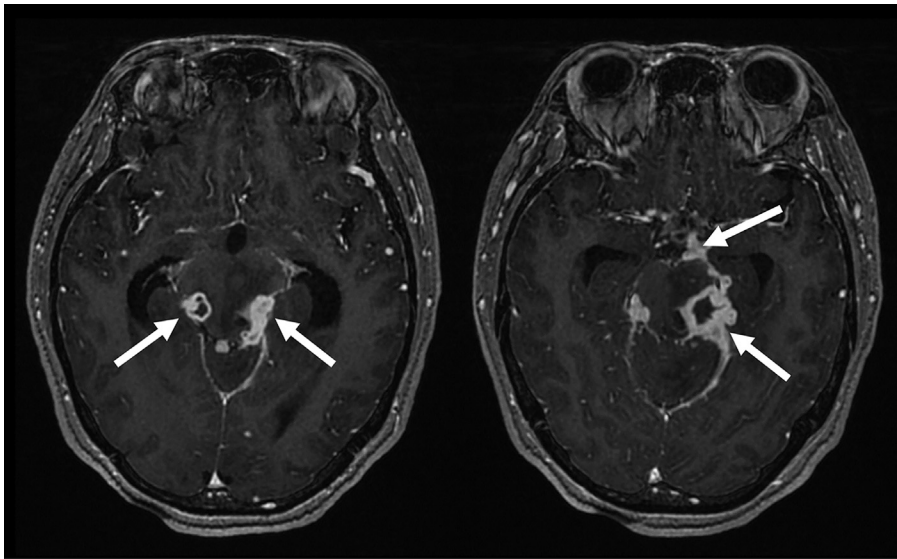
Tuberculous meningitis. Axial T1-weighted postcontrast MR imaging shows thick nodular meningeal enhancement at the basal cisterns with abscess formation (arrows).
